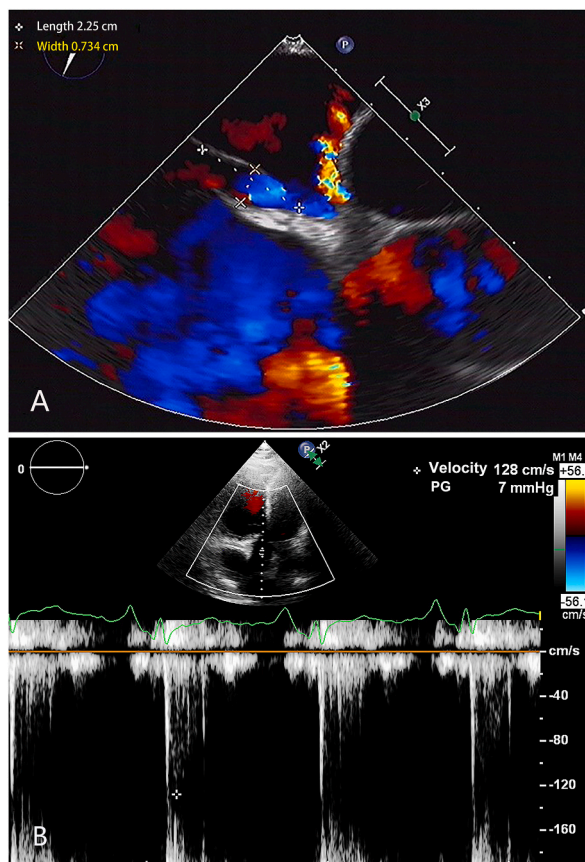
Transesophageal echocardiography showing a patent foramen ovale (PFO) with a diameter of approximately 7.34 mm, displaying continuous right-to-left shunt through the PFO (A) at a velocity of 1.28 m/s (B).
